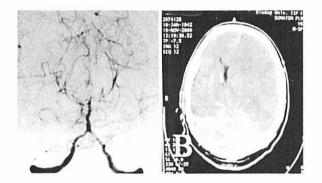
2A. Cerebral angiography (AP) immediately after coil embolization demonstrated severe vasospasm of both vertebral arteries. 2B: Axial non-contrastenhanced CT scanning 18 hours after embolization demonstrated hemispheric infarction with midline shift.
